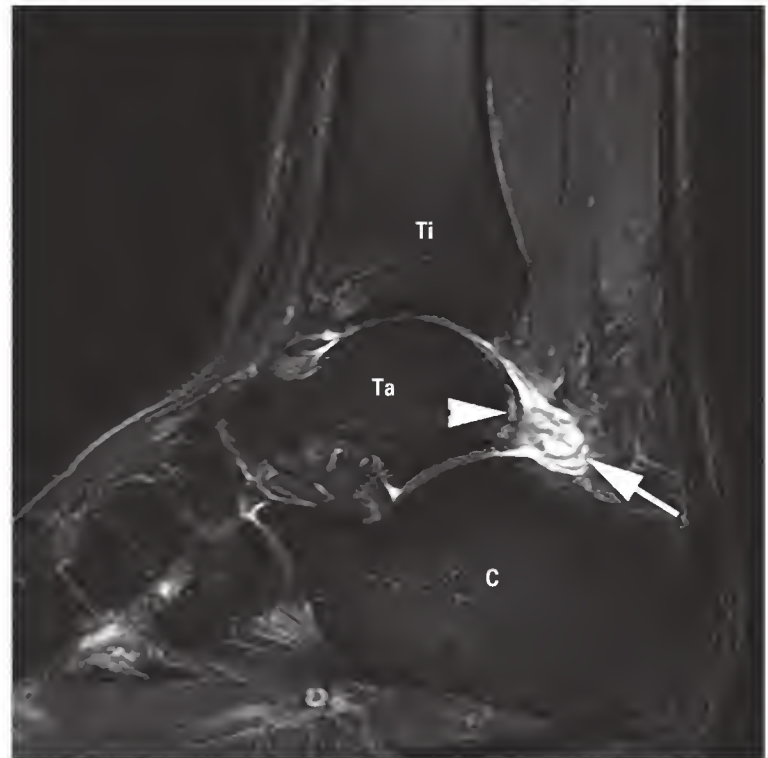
Sagittal T2-weighted magnetic resonance image showing posterior synovitis (arrow) and posterior talar edema (arrowhead). C, calcaneus; Ta, talus; Ti, tibia. (From Conaghan PG, O'Connor P, Isenberg D, editors. *Musculoskeletal imaging. Oxford specialist handbooks in radiology*. Oxford: Oxford University Press; 2010. With permission.)
